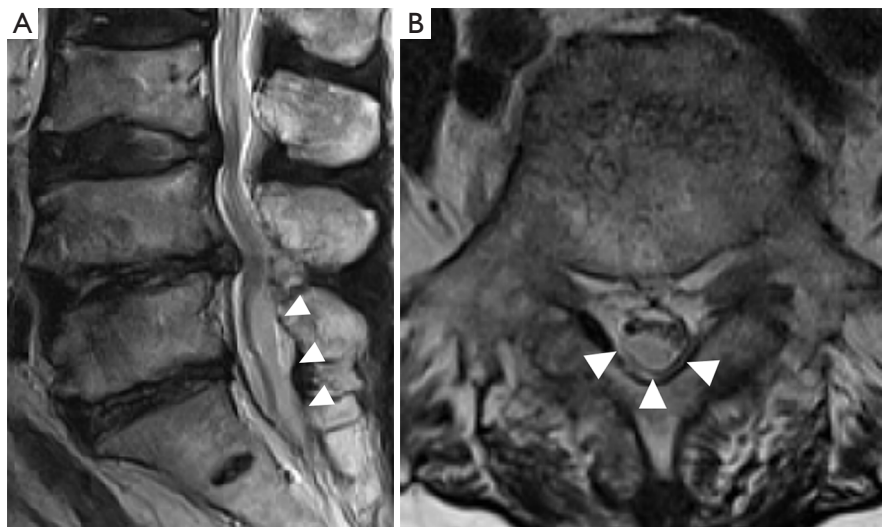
Sagittal (A) and axial (B) magnetic resonance images taken 7 days after full-endoscopic decompression surgery show development of the spinal subdural hematoma at the L5–S1 level.
